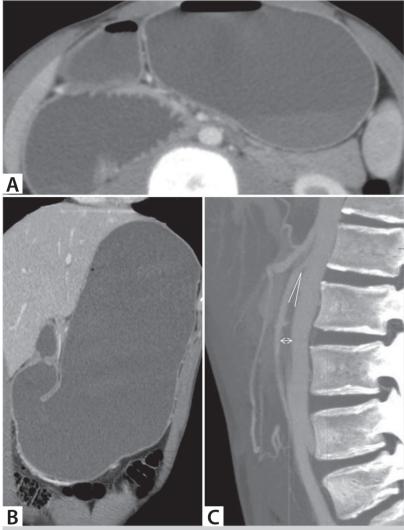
A. Axial and B. coronal CT scans show excessive stomach dilation. C. Sagittal CT scan shows narrowed SMA-Aort angle (Patient 1).
